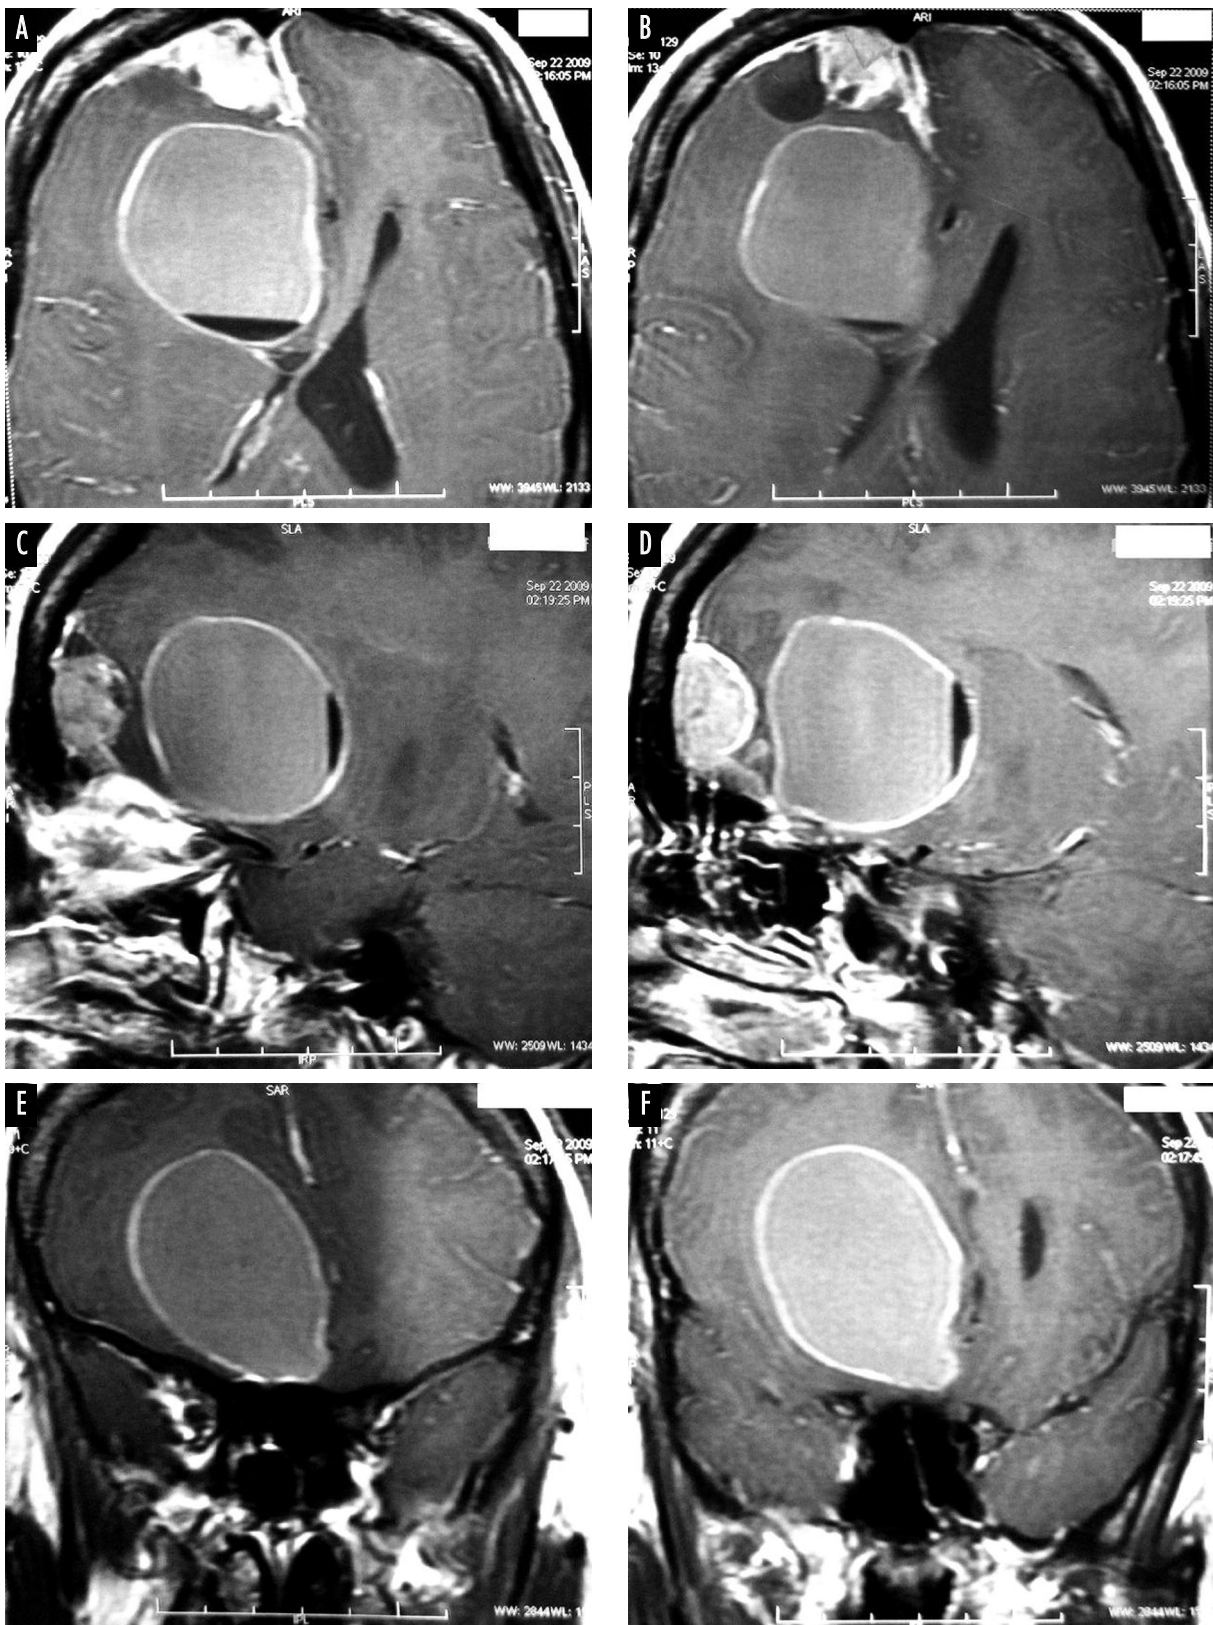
T1-weighted gadolinium-enhanced MRI of the brain (A – axial section; B – sagittal section; C – coronal section) reveals an extra-axial lesion with mixed signal intensity and with solid cystic component in the right frontal lobe measuring $1.7 \times 2.5 \times 3.3$ cm with a large right paramedian cystic component measuring $3.8 \times 3.9 \times 4.4$ cm. The lesion has a broad base overlying the frontal convexity with subfalxine herniation. Heterogeneous post-contrast peripheral rim enhancement, midline shift and dilatation of the occipital horn of the left lateral ventricle are noted
